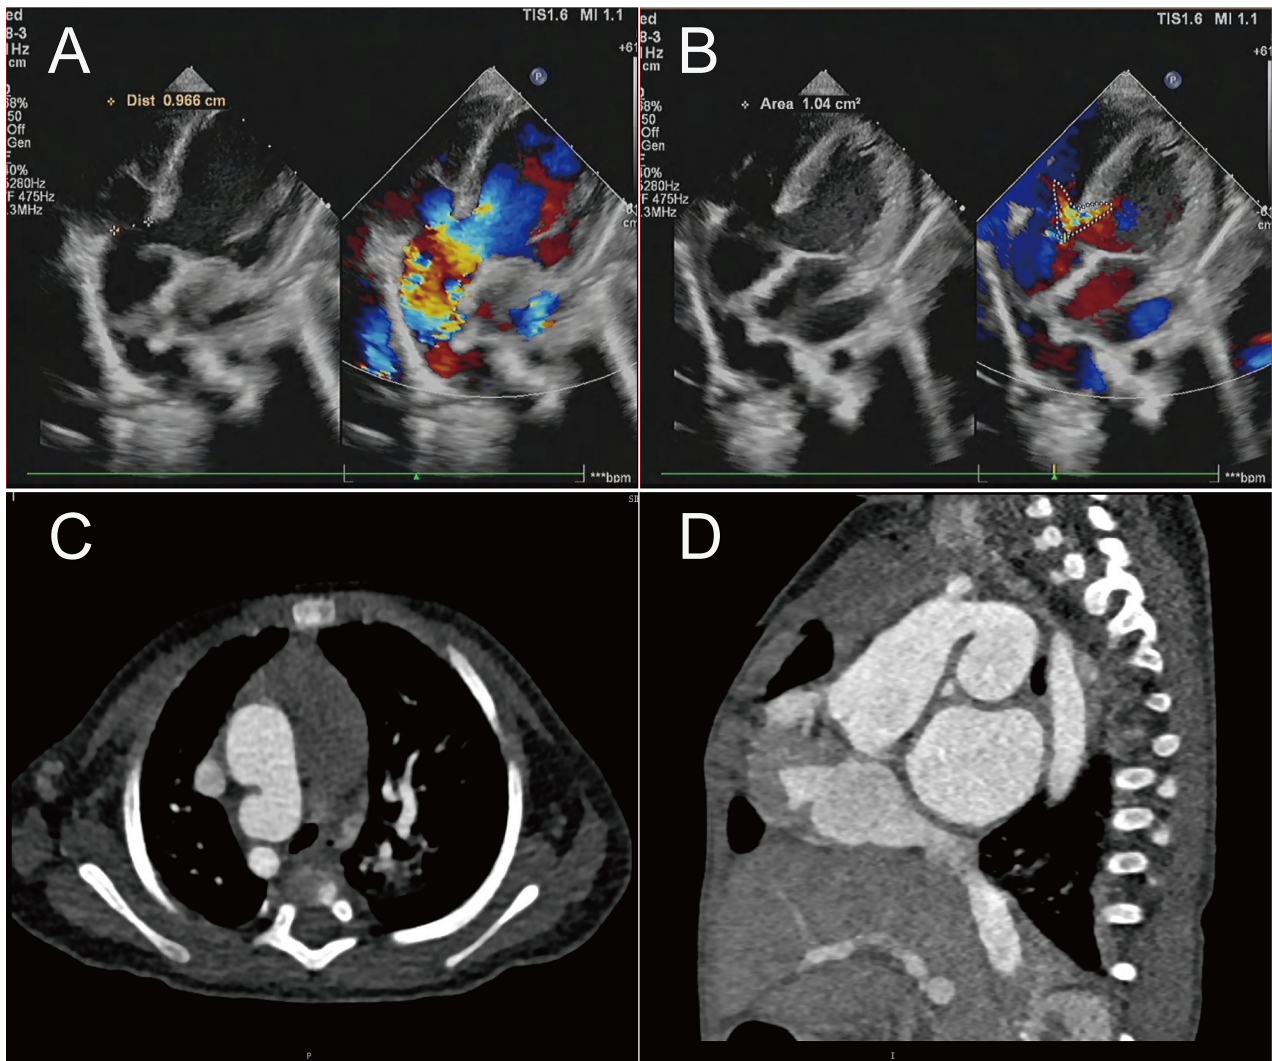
The preoperative transthoracic echocardiogram and computed tomography findings. (A) The main pulmonary artery was derived from the left posterior wall of the common trunk 14 mm above the level of the truncus valve with a 9.0 mm opening. (B) The ventricular septal defect was 10 mm in size with a bi-directional shunt. (C) The right aortic arch with the right descending aorta was revealed on computed tomography. There was a 7 mm connection between the aortic arch and the main pulmonary artery. (D) The main pulmonary artery arose from the posterior wall of the common trunk.
